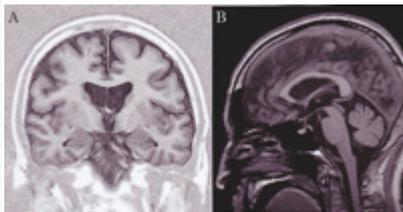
(A) Coronal and (B) sagittal T1 weighted magnetic resonance imaging of the brain
